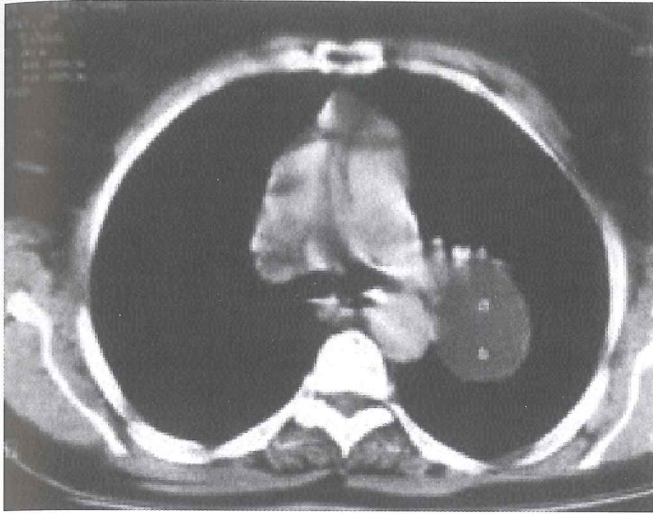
CT scan showing a cystic mass, placed at the left hilum. The cyst has a communication with the left bronchial system.
